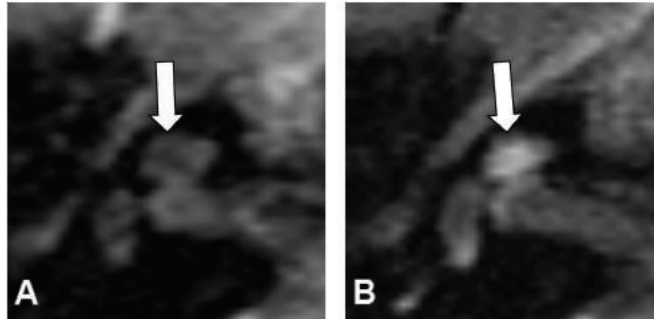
Variable cochlear enhancement at different postmeningitic time intervals. Axial gadolinium enhanced T1-weighted MRI of same patient (Patient 11). A, after 3 days, B, after 51 days.
